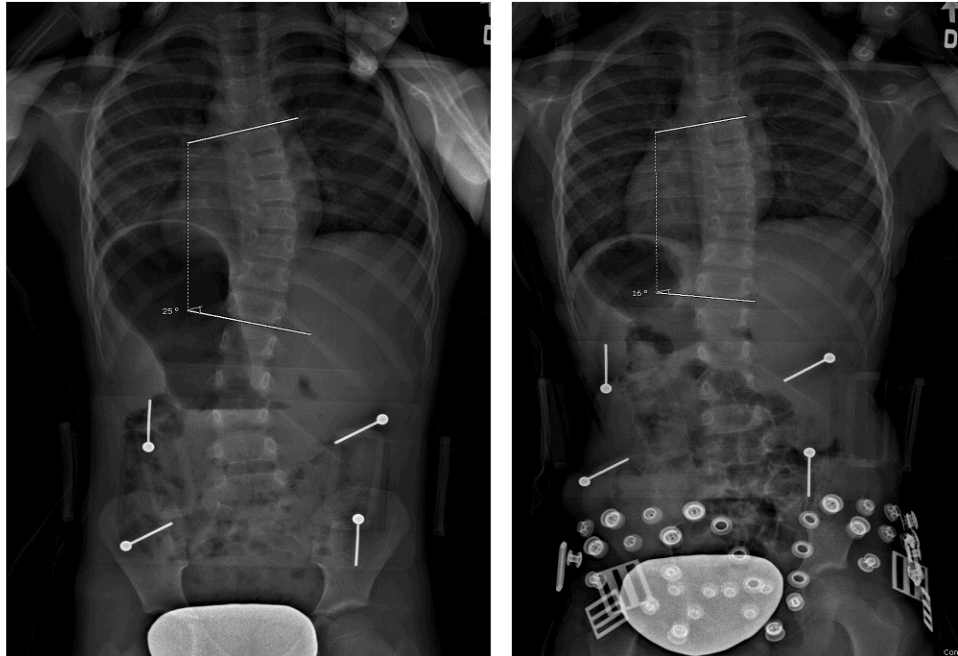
x-Ray of a scoliotic patient before and immediately after the fitting of the SpineCor Brace (Right thoracic type 1)
